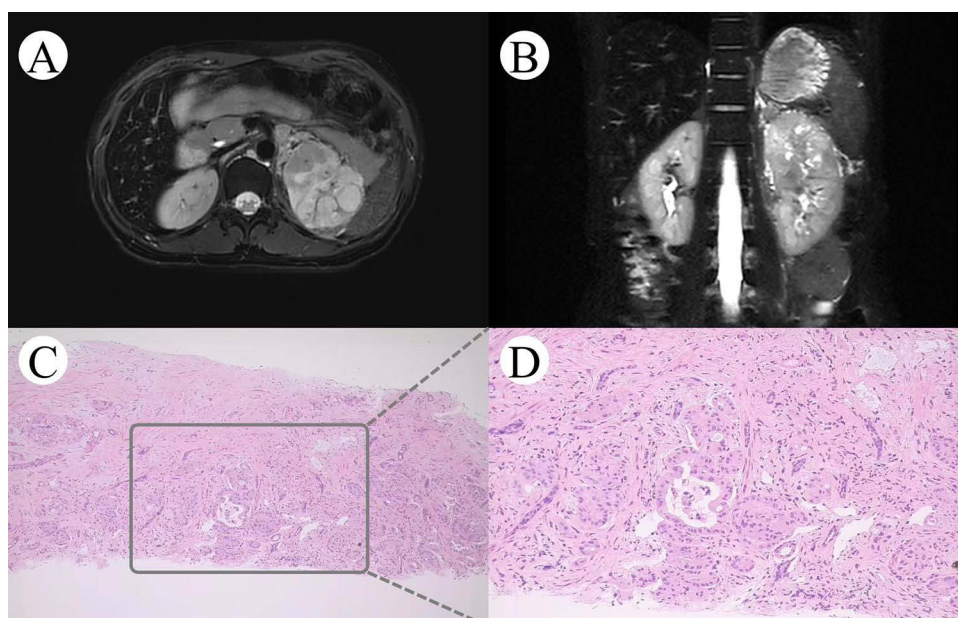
(A) renal MRI transverse plane. (B) renal MRI coronal plane. (C) and (D) pathologic images of left kidney biopsy.
